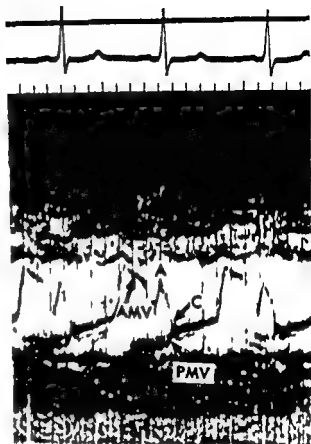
Mitral valve echocardiogram of the patient referred to in Fig 9 taken after correction of the paraprosthetic leak.
